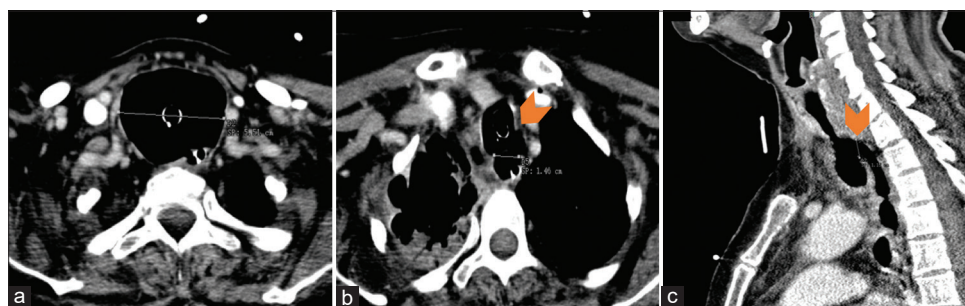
Computerized tomography (CT) scan performed on day 22 of MV. a – Axial view showing tracheomalacia and tracheal maximal transverse diameter of 55 mm, with a deflated cuff. b and c – Axial and sagittal views, respectively, showing a tracheoesophageal fistula (TEF) between the posterior tracheal wall and the esophagus, measuring 15 × 20 mm. Arrowhead – TEF
